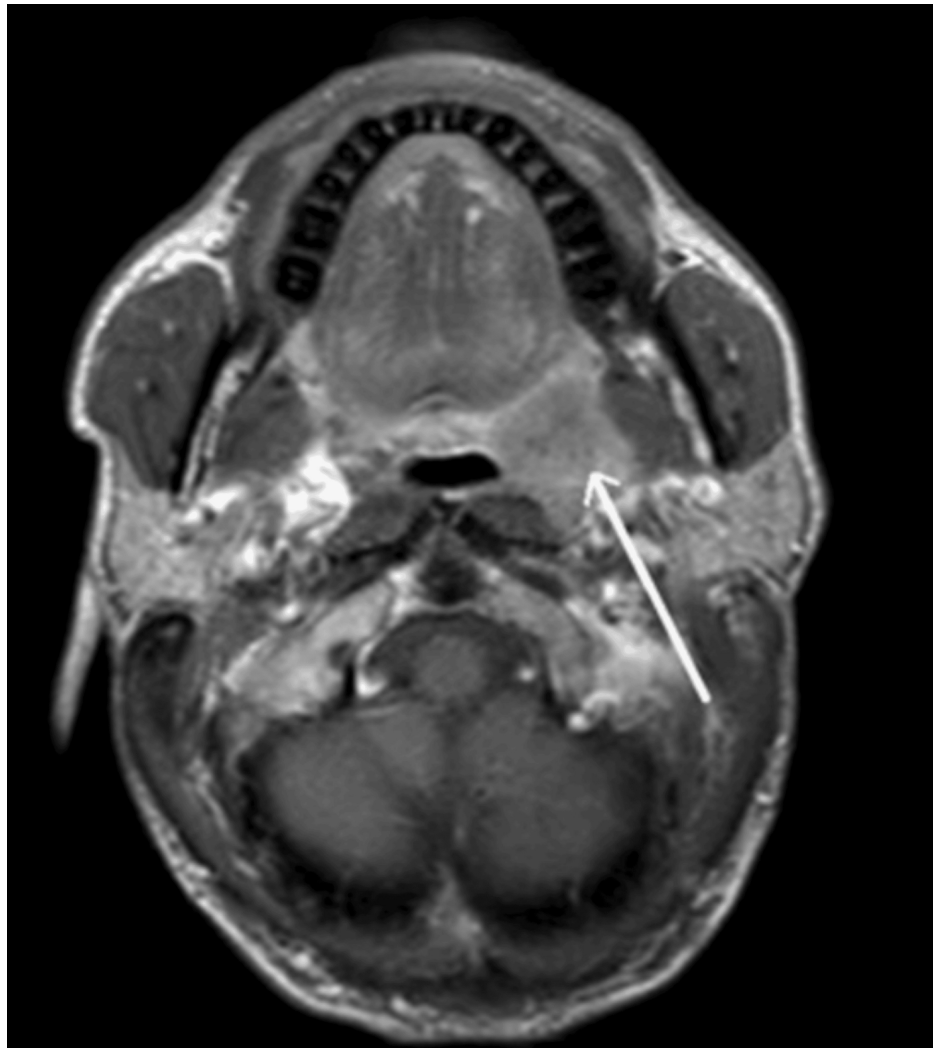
Magnetic resonance imaging (MRI) of the skull, T1-weighted scan.
